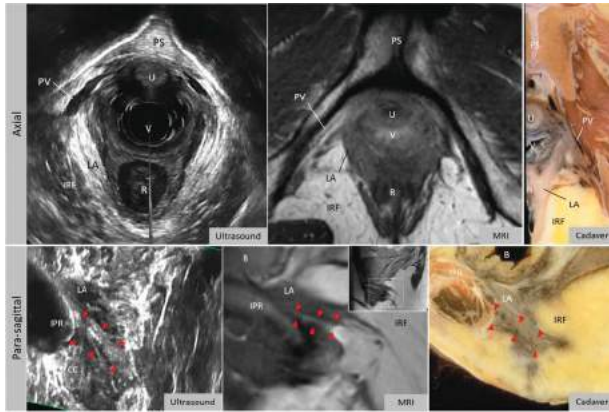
Perineal membrane (between red arrowheads) and its surrounding structures in axial (top row) and sagittal planes (bottom plane) on 3D transvaginal ultrasound and MRI, as labeled. On the right, coronal section of a 33-year-old female cadaver with normal support. Note that the perineal membrane is not marked on the axial images as this plane is tangent to it. V denotes vagina; U, urethra; R, Rectum; B, Bladder; LA, Levator ani muscle; IRF, Ischio-rectal fossa; PS, pubic symphysis; CC, Crus of clitoris; and PV, Pudendal vessels.
